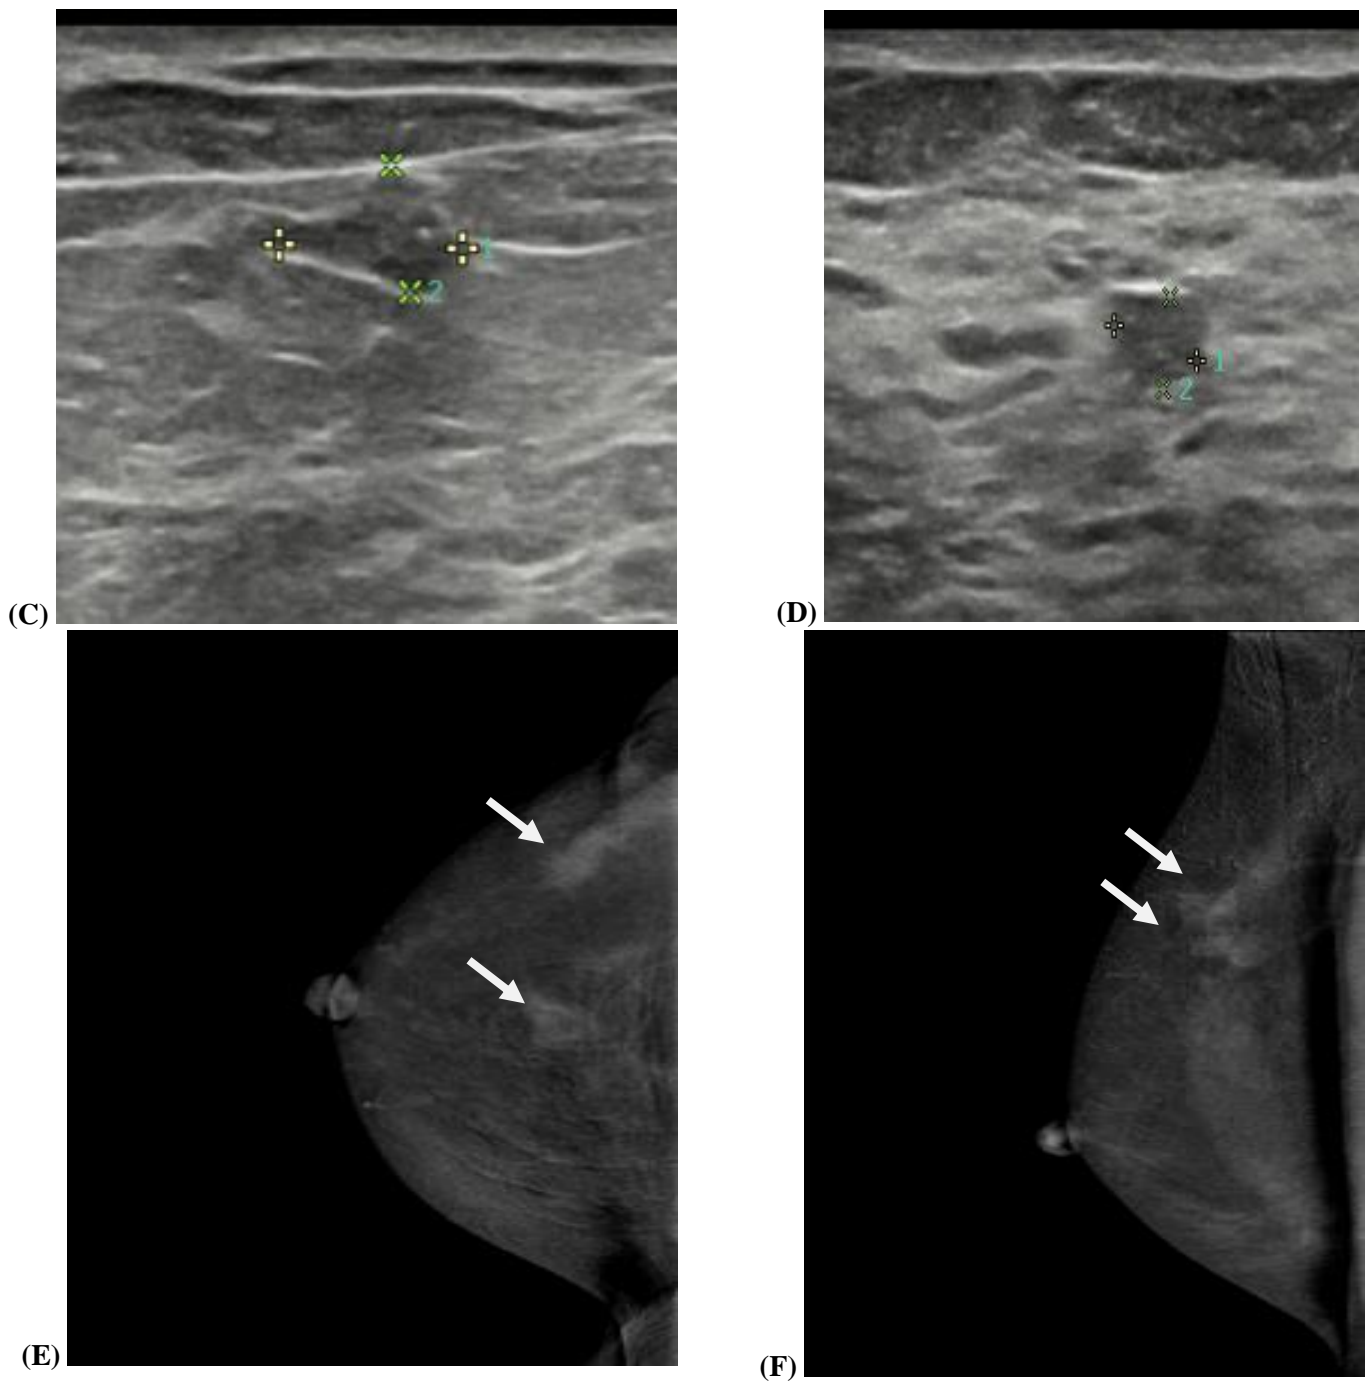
A 65-years-old female coming for breast screening. (A-B) CC, MLO of DM of right breast revealed right upper central quadrant ill-defined lesion partially obscured by condensed glandular tissue. (C-D): ultrasound revealed ill-defined 2 oval lesions with angular and microlobulated margins and they were categorized as BI-RADS 4. (E-F): CEDM of the right breast in CC and MLO views revealed 2 enhancing irregular lesions. The lesions were upgraded to BI-RADS 5. Tissue core biopsy revealed multifocal invasive ductal carcinoma.
